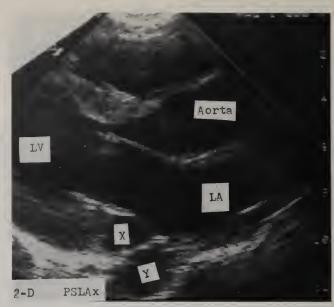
Two-dimensional echocardiogram. X marks the dilated CS.
